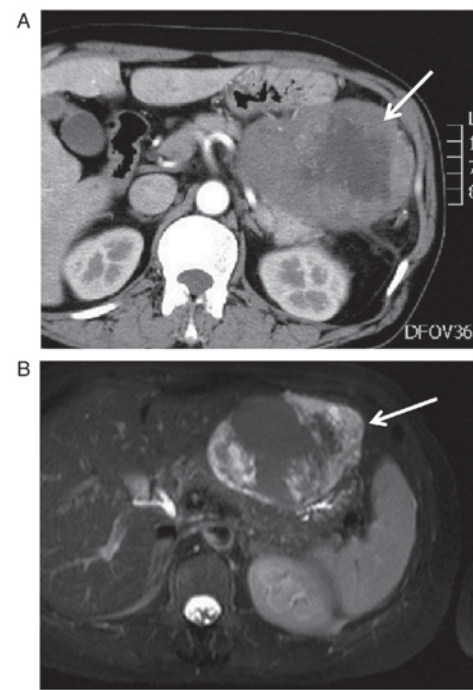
Radiological characteristics of GISTs. (A) Computed tomography scan (arterial phase): The lesion is indicated by the arrow. GIST of the stomach demonstrating a thickening of the gastric wall, with slight to moderate inhomogeneous enhancement following contrast agent injection. Lymph nodes around the mass exhibited reactive hyperplasia. (B) Magnetic resonance imaging (T2-weighted): The lesion is indicated by the arrow. GIST of the stomach sized ~9x7 cm and exhibiting heterogeneous hyperintense T2 signals. GIST, gastrointestinal stromal tumor.
